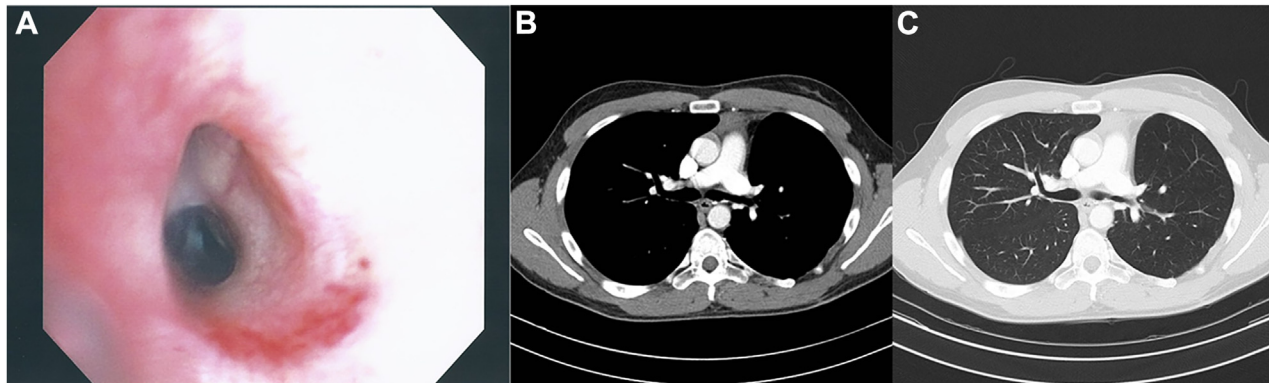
(A) Surveillance flexible bronchoscopy 48 months after resection. (B, C) Surveillance computed tomography 80 months after resection.
